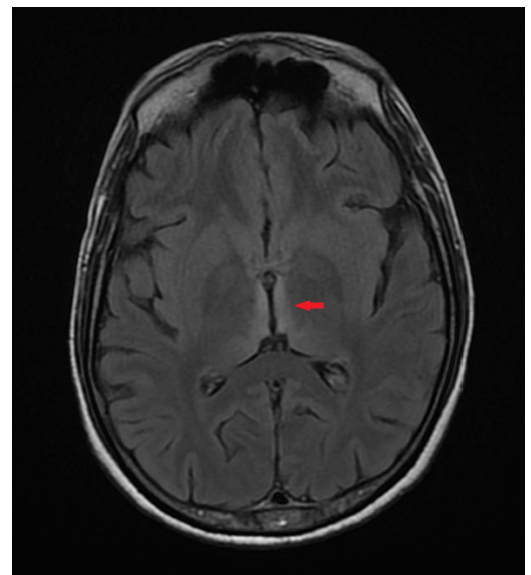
Symmetrical non-enhancing T2-weighted and fluid-attenuated inversion recovery hyperintensity with diffusion restriction seen in the paramedian ventromedial thalami.
